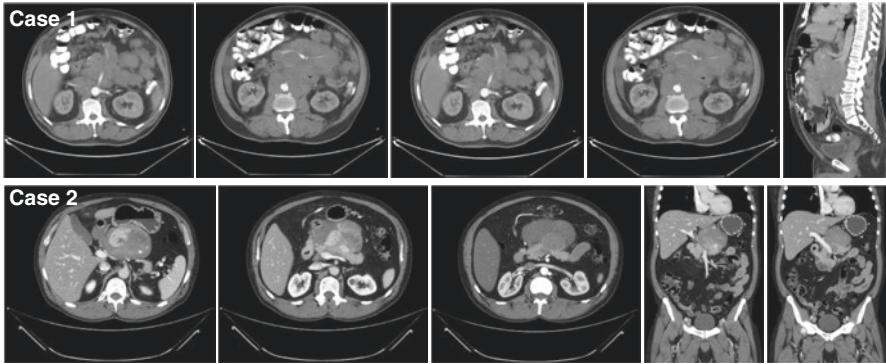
Case 1 – Diffuse non-Hodgkin’s lymphoma of large B cells. The mass represents a lymph node conglomerate. When all CT sections are observed in detail, the presence of lymphadenomegaly is also noted in the latero-cava, intercavo-aortic, and later aortic chains. Case 2 – Dedifferentiated liposarcoma. Note on the CT the aspect of an expansive solid lesion, with a hypervascularized component and areas of liquefaction/necrosis, with an infiltrative aspect, occupying the epiploic retro cavity, with densification of adjacent fatty planes. Despite the dimensions and aspect of a high-grade lesion, there is no associated lymphadenomegaly
